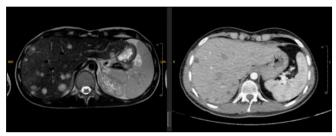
Comparison of tomography taken during the first two months of treatment with the initial MR (Magnetic Resonance) images (The left panel shows the pre-treatment MR images, and the right panel shows the CT images taken two months after the start of treatment.)
